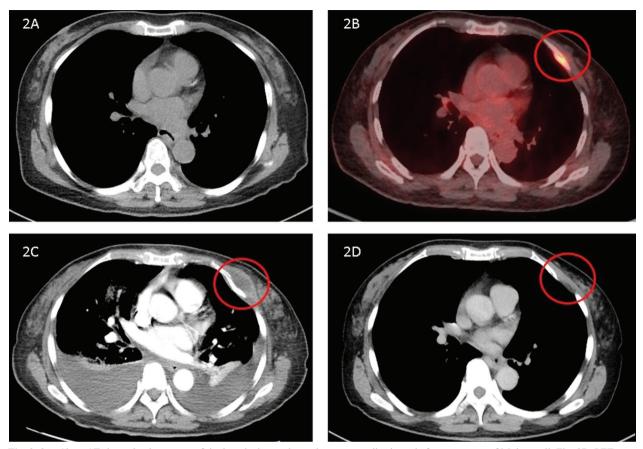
2A. Chest CT showed enlargement of the lymphadenopathy at the upper mediastinum before treatment of M. kansasii. Fig. 2B. PET scan revealed bone/ marrow avidity at the left rib cage. Fig. 2C. Chest CT showed progression of the left chest wall tumor and bilateral pleural effusion. Fig. 2D. Chest CT identified improvement in the left chest wall tumor and in the bilateral pleural effusion after 3 months of treatment.
